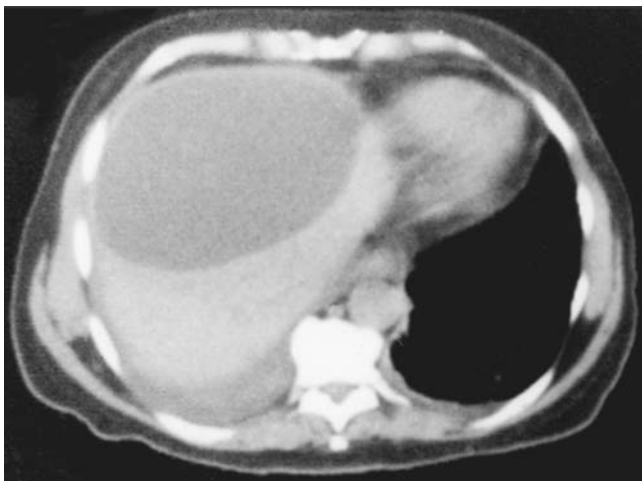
CT scan demonstrating biloma associated with biliary leak after bile duct injury. (Reprinted, with permission, from Lillemoie KD, Pitt HA, Cameron JL. Postoperative bile duct strictures. *Surg Clin North Am.* 1990;70:1362.)
